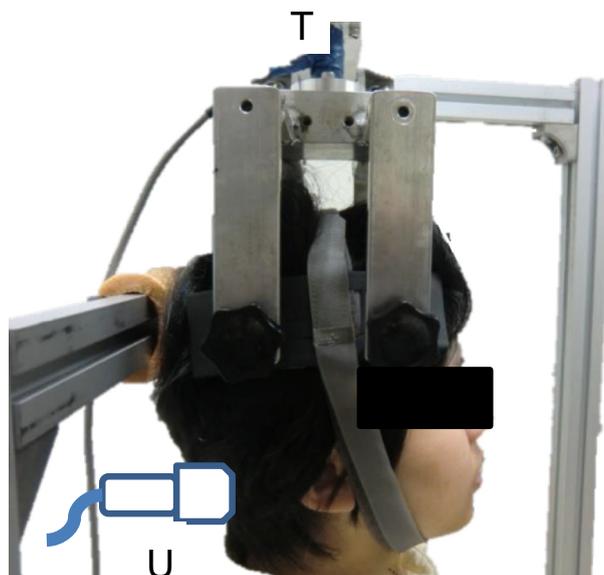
The setting for detecting the thickness of the oblique capitis inferior and the torque during isometric head rotation. T, torque load cell; U, ultrasound.
